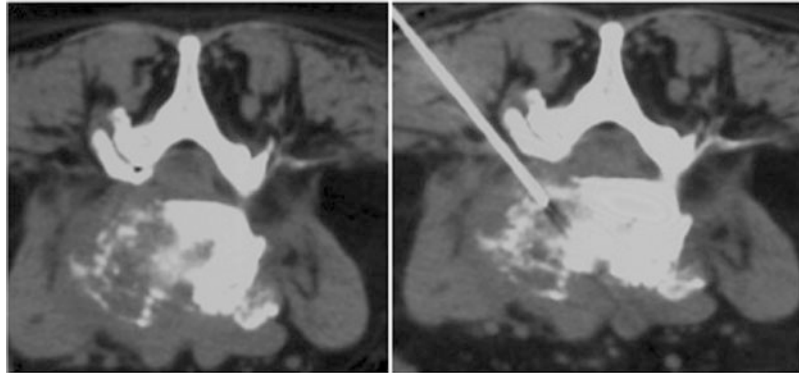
CT-guided multiple sampling of a secondary tumor in the vertebral body. Different positions of the needle: on the skin surface (a), in the medial part of the vertebral body (b) and in left lateral position within the vertebral body (c)
